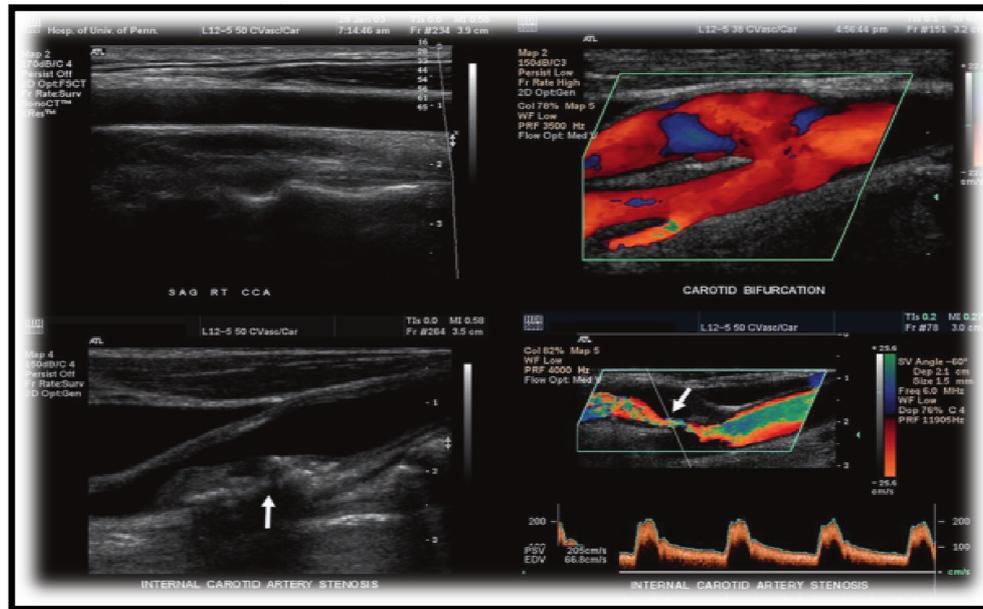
Ultrasound images of carotid artery. The two top figures show a normal gray-scale on the left and a normal color Doppler of the carotid bifurcation. The lower left gray-scale image shows arteriosclerotic plaque and debris. The color Doppler on the right indicates the marked degree of stenosis (arrows). [15]
